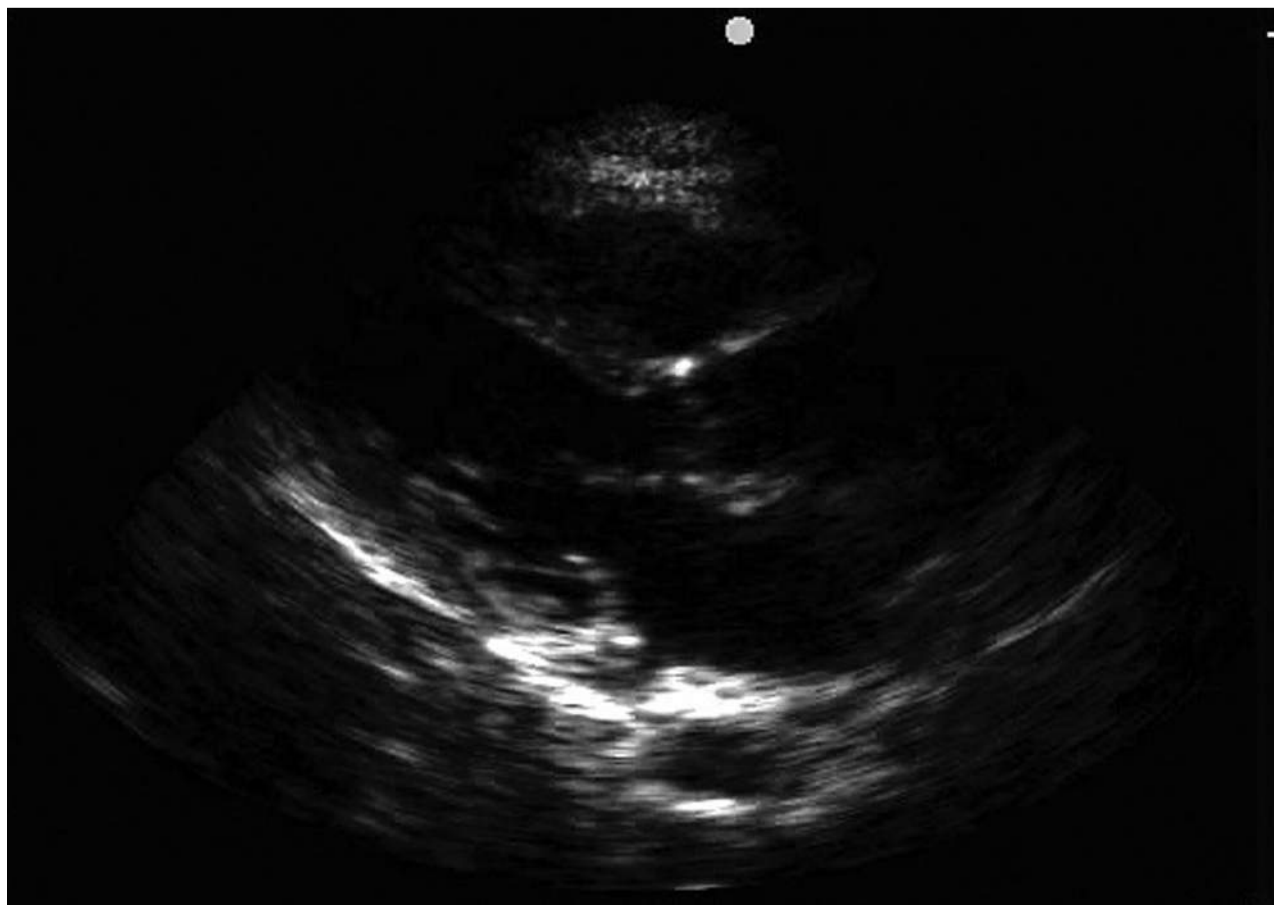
Parasternal long-axis view, low ejection fraction, abnormal mitral valve (MV) motion. Parasternal long-axis view during mid-diastole showing maximal MV opening in a heart with abnormal systolic function. Note that the anterior MV leaflet is > 1 cm from the septum, indicating elevated left ventricular (LV) pressure and diminished LV function.
